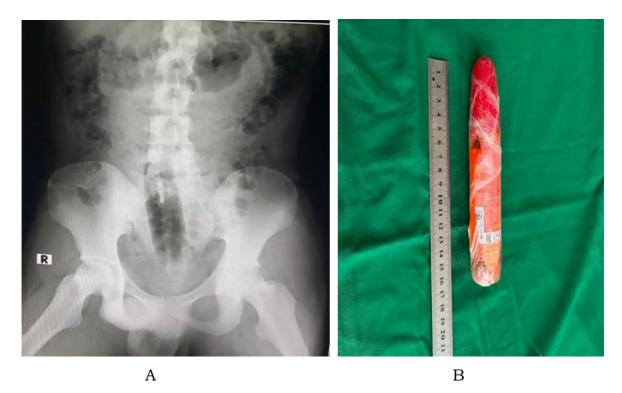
A. Plain abdominal radiograph reveals a tubular foreign body. B. Residual foreign body in the rectum postextraction.
